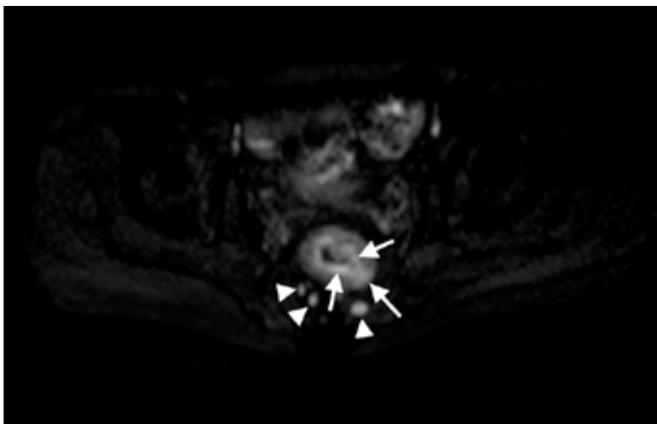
Transverse DWI image with high B-value taken through the mid-rectum following chemoradiotherapy shows areas of residual tumour as bright areas within the rectum and mesorectum (arrows) as well as in involved lymph nodes in the mesorectum (arrowheads) (Stage T3N1). Case courtesy of Dr Natalie Yang, Radiopaedia.org, rID: 7135.
